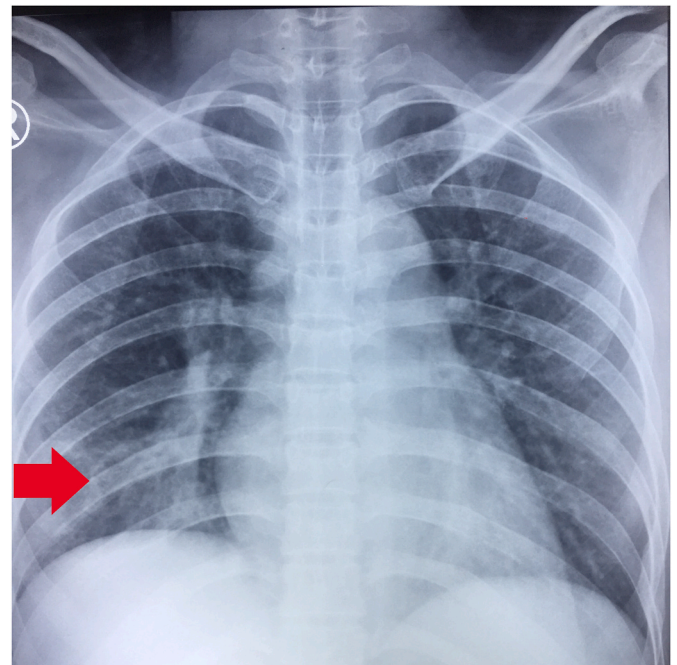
Chest X-ray anterior-posterior showed infiltrate in right inferior lobe of the lung.
